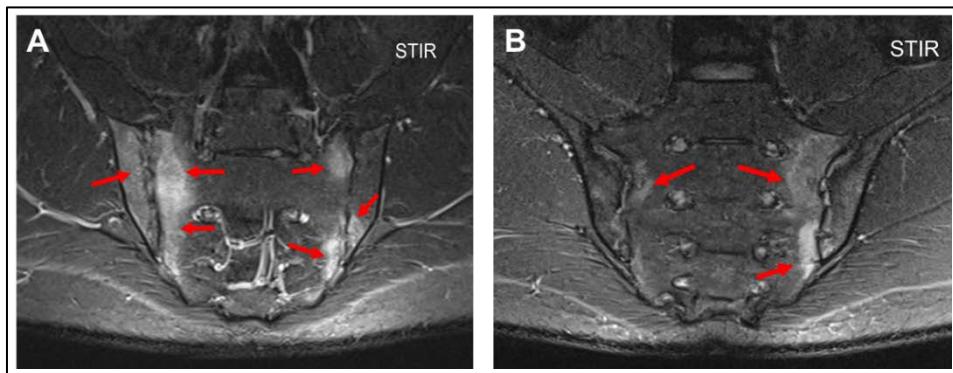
Lesiones inflamatorias activas de las SIJs detectadas por MRI de dos pacientes (STIR, del inglés *short tau inversion recovery*). Las flechas rojas indican edema de médula ósea subcondral. Modificado de ASAS website.
